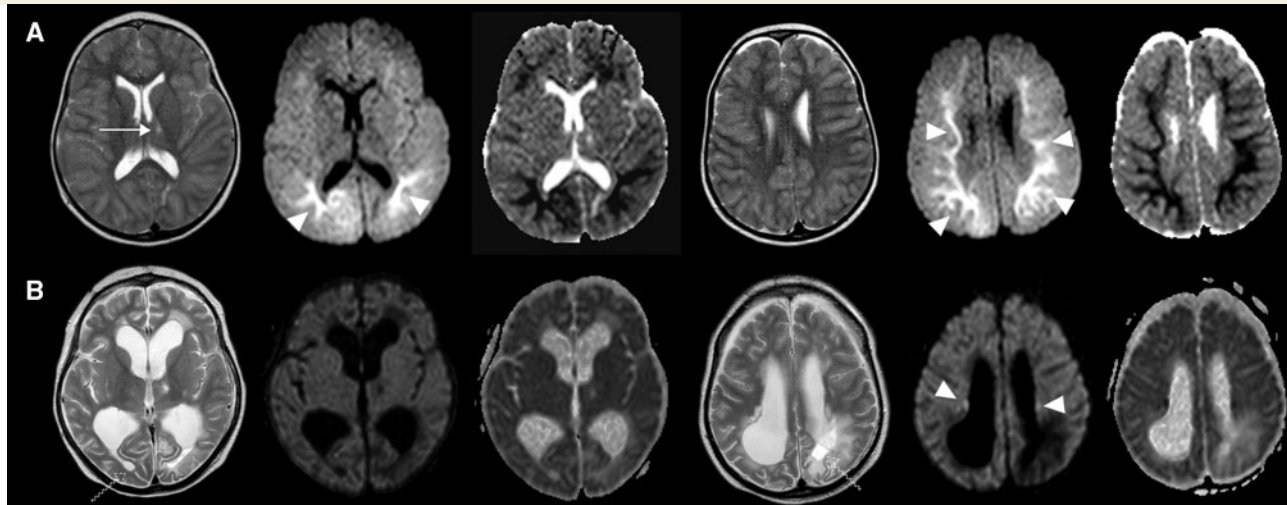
Brain MRI of the index patient at the ages of 8 and 12.5 years. From left to right: Axial T₂, apparent diffusion coefficient (ADC) and diffusion-weighted imaging (DWI) sequences (at two different layers, respectively). (A) Brain MRI at 8 years of age. Small lacunar thalamic lesion (arrow) without ADC reduction and without further basal ganglia or cortical signal alterations, T₂-weighted sequences. Symmetric extent and diffuse signal increases of the white matter with periventricular predominance, DWI sequences. ADC maps show an ADC decrease in the corresponding white matter (arrowheads). (B) Brain MRI at 12.5 years of age. Biventricular *ex vacuo* hydrocephalus, brain atrophy with rarefaction of the white matter, extent symmetric white matter signal changes most pronounced in periventricular areas and parietooccipital lobes, in part with cystic appearance on T₂-weighted sequences (dashed arrows). Some patchy white matter areas show an increased signal in DWI sequences compatible with an ongoing process of white matter affection (arrowhead).
